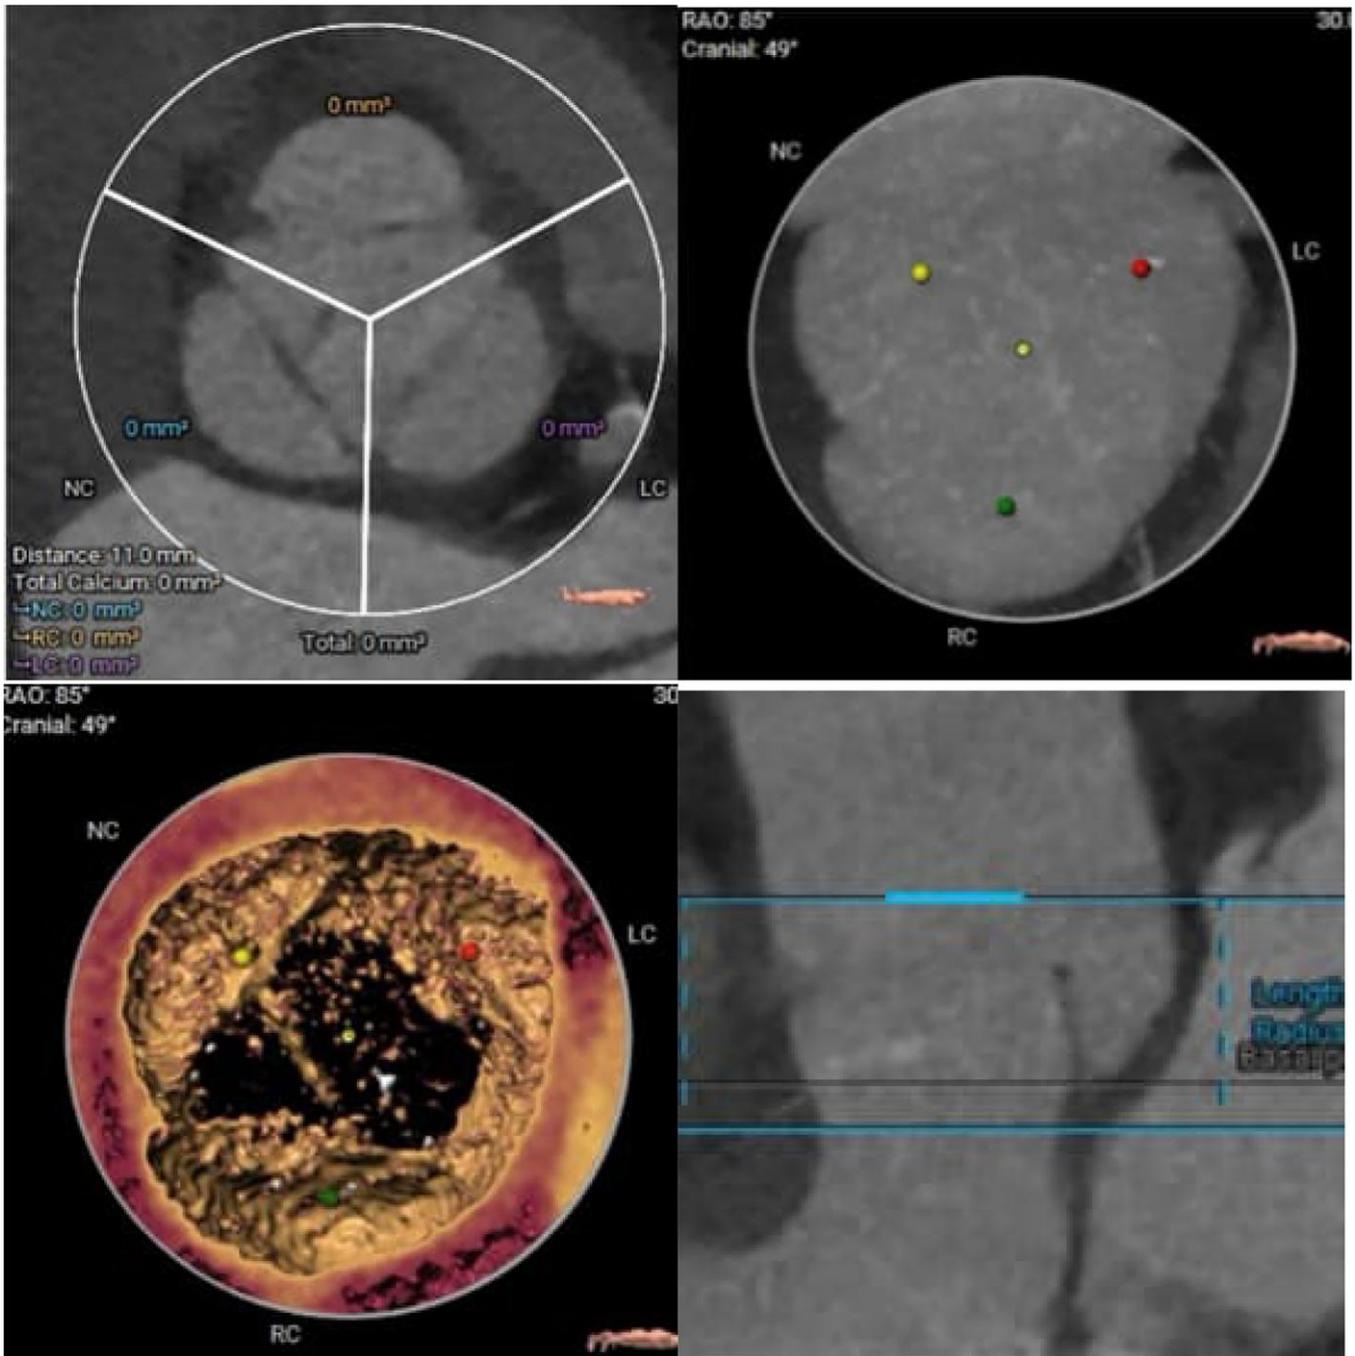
Cardiac computed tomography (CT) scan images showing the absence of calcification in the aortic valve. [Color figure can be viewed at wileyonlinelibrary.com]
